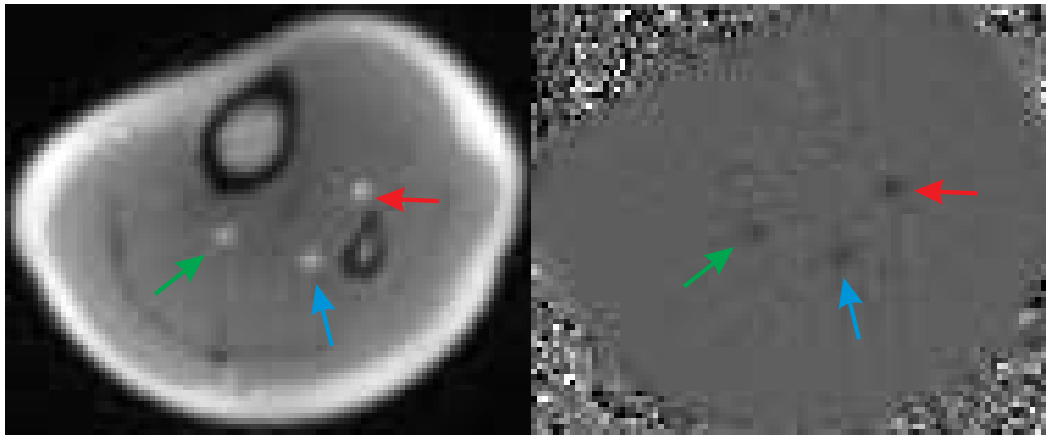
Magnitude image (left) and phase-contrast map (right) of peripheral arterial flow obtained from lower limbs at the region of the calf muscles using real-time PC MRI. Region of interests include anterior tibial artery (green), peroneal artery (blue) and posterior tibial artery (red).
